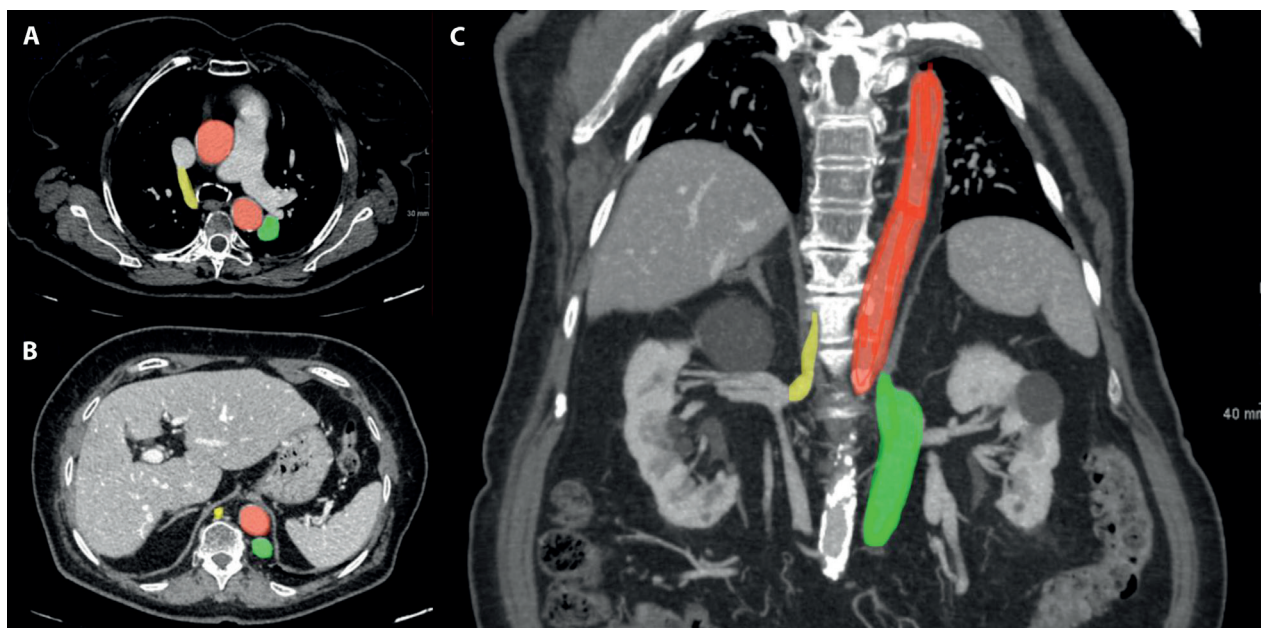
Portal phase of a Whole-Body CT scan with MIP application. a) axial plane showed the typical azygos arch. b) axial plane showed from right to left the azygos vein, the aortae, and the enlarged hemiazygos. c) coronal plane showed the azygos overpassing the diaphragmatic pillar at the L1-L2 level and its confluence with the right renal vein and the transhepatic continuation. Yellow: azygos; Red: aortae; Green: hemiazygos.
